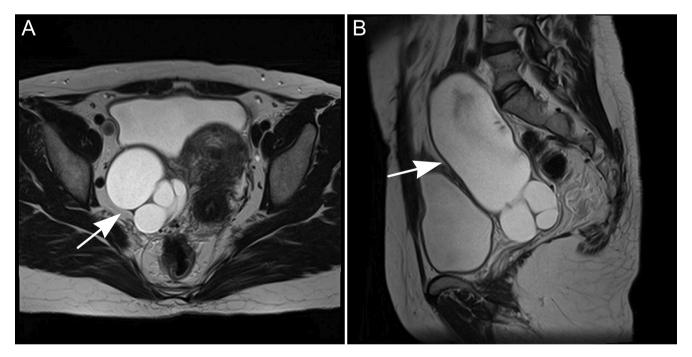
Pelvic T2-weighted MRI demonstrated a dilated tubular structure on the right side of the uterus, measuring approximately  $14.0 \times 6.0 \times 5.5$  cm (arrows). The sagittal image exhibited focal T2 shading in the dilated lumen (B), indicative of right hematosalpinx.
